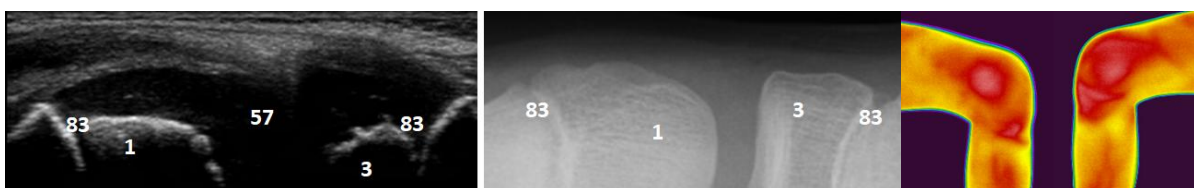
sono, Fig.12b.radiograph, Fig.12c.TMV medially. Sono: hypoechogenic filling of the recessus genus medialis. X-ray: normal findings of growth plates. TMV: increased thermal activity of the medial articular recessus and in the area of the growth plates of the medial condyle of the femur and tibia bilaterally. 1. condylus medialis femoris, 3. condylus medialis tibiae, 57. hydrops, 83. growth plate.
